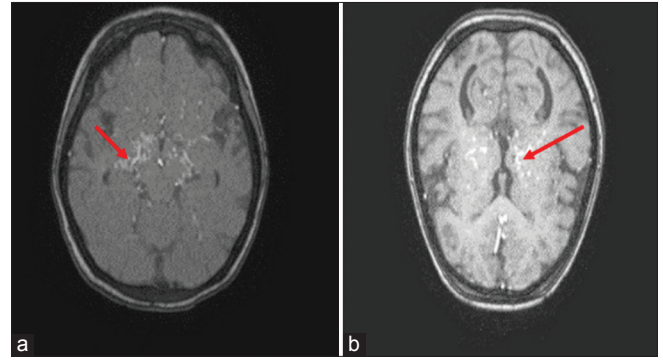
(a) Magnetic resonance (MR) angiogram source image showing multiple collaterals in basal cisterna (arrow), (b) T1W post-contrast MR image showing multiple collaterals in thalami (arrow)
